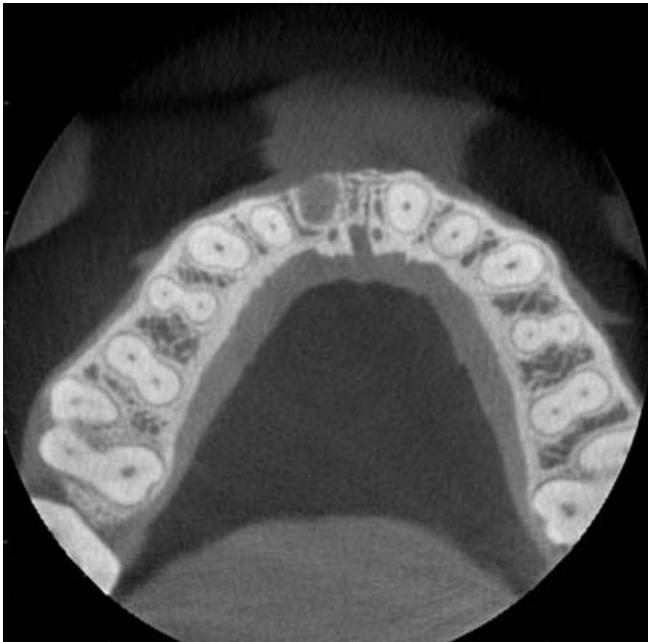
Axial CBCT slice
